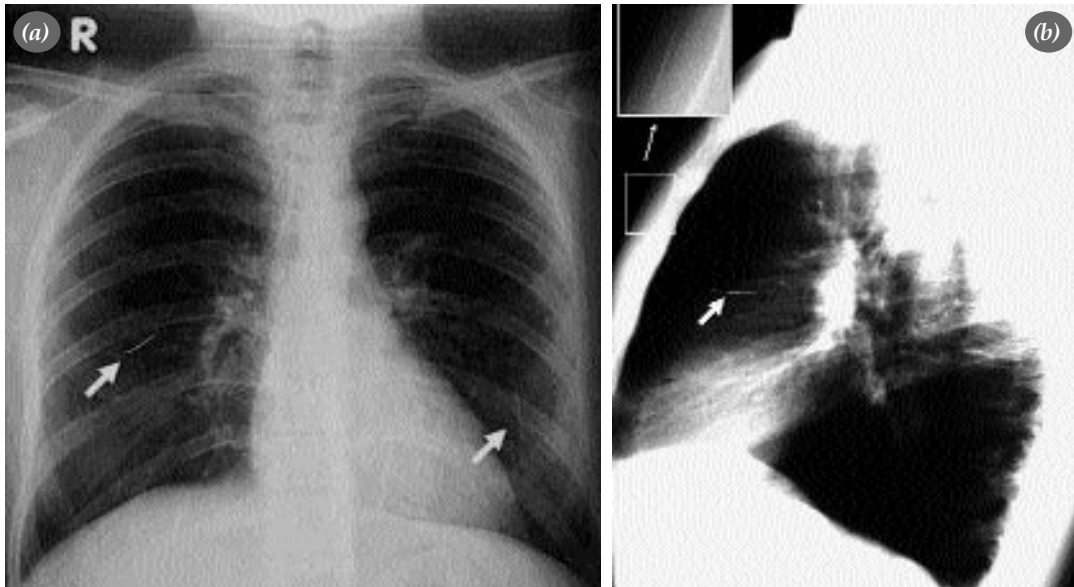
(a) A posteroanterior chest radiograph showing three needles, one in the right middle zone, and two in the left paracardiac region. (b) On a lateral radiograph, a needle is seen in the subcutaneous and retrosternal region.
